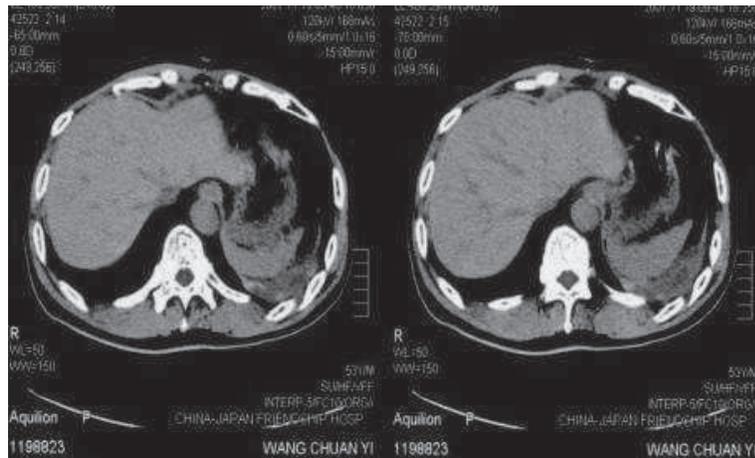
CT scan before EChT
